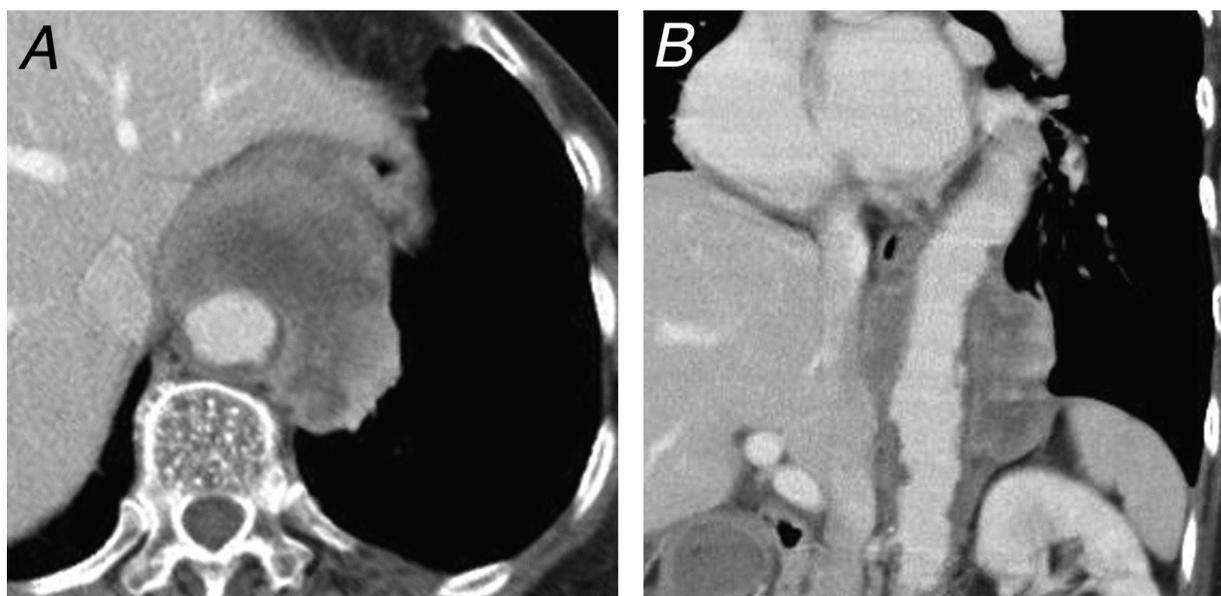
A*, The axial postcontrast chest computed tomography image immediately before surgery shows a markedly enlarged, heterogeneously enhanced, saccular-shaped mass surrounding the aorta, corresponding to the infected thoracoabdominal aortic aneurysm. The aortic wall lacked calcification and was irregularly in contact with the mass surrounding the aorta. *B*, Coronal reconstructions show the saccular-shaped mass extending vertically across the thoracoabdominal aorta.
